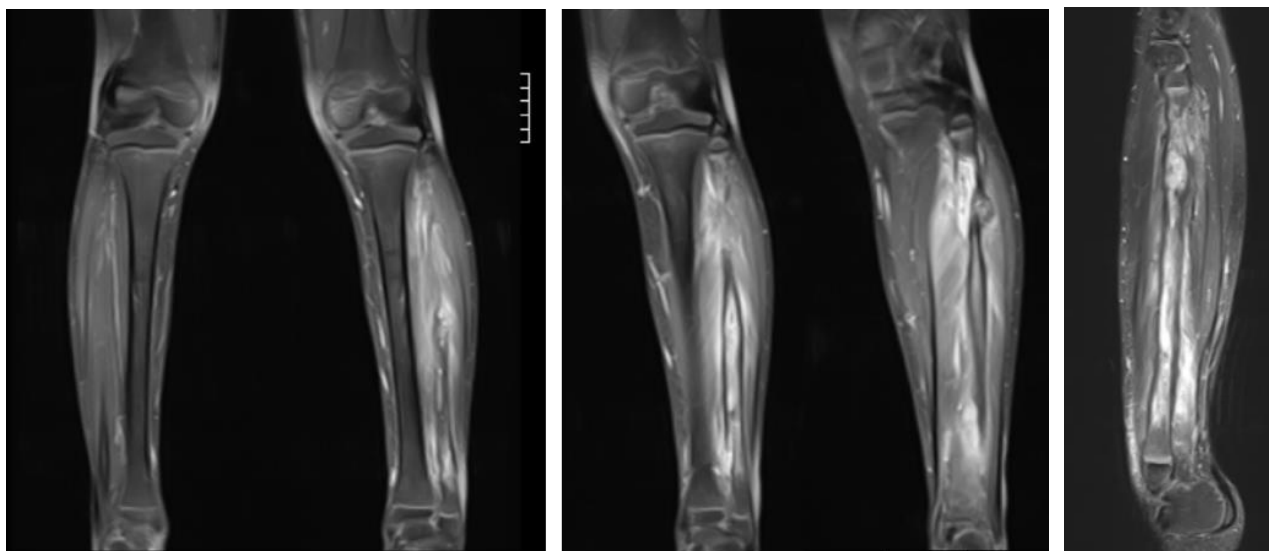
Left leg MRI showing hyperintensity representing bone marrow edema, as well as intraosseous abscess, characteristic of hematogenous osteomyelitis. There is a non-union fracture at the proximal shaft of the left fibula as well as marked periosteal thickening throughout the fibula
